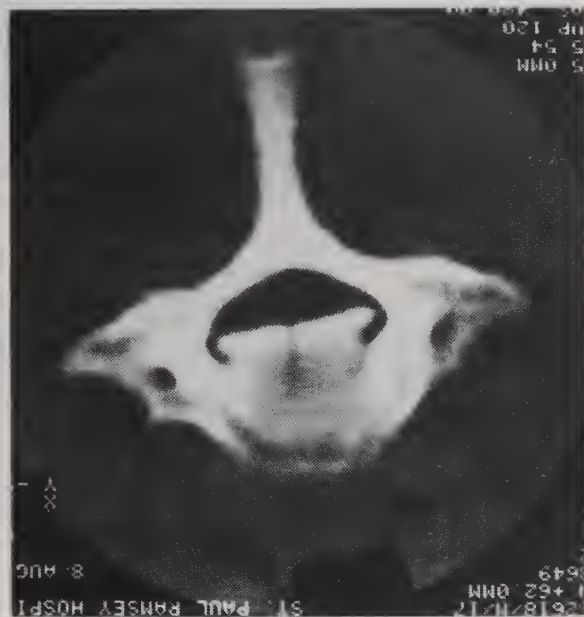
(A) — CT scan of neurologically intact patient with marked reduction in AP diameter of the spinal canal due to C7 burst fracture.
